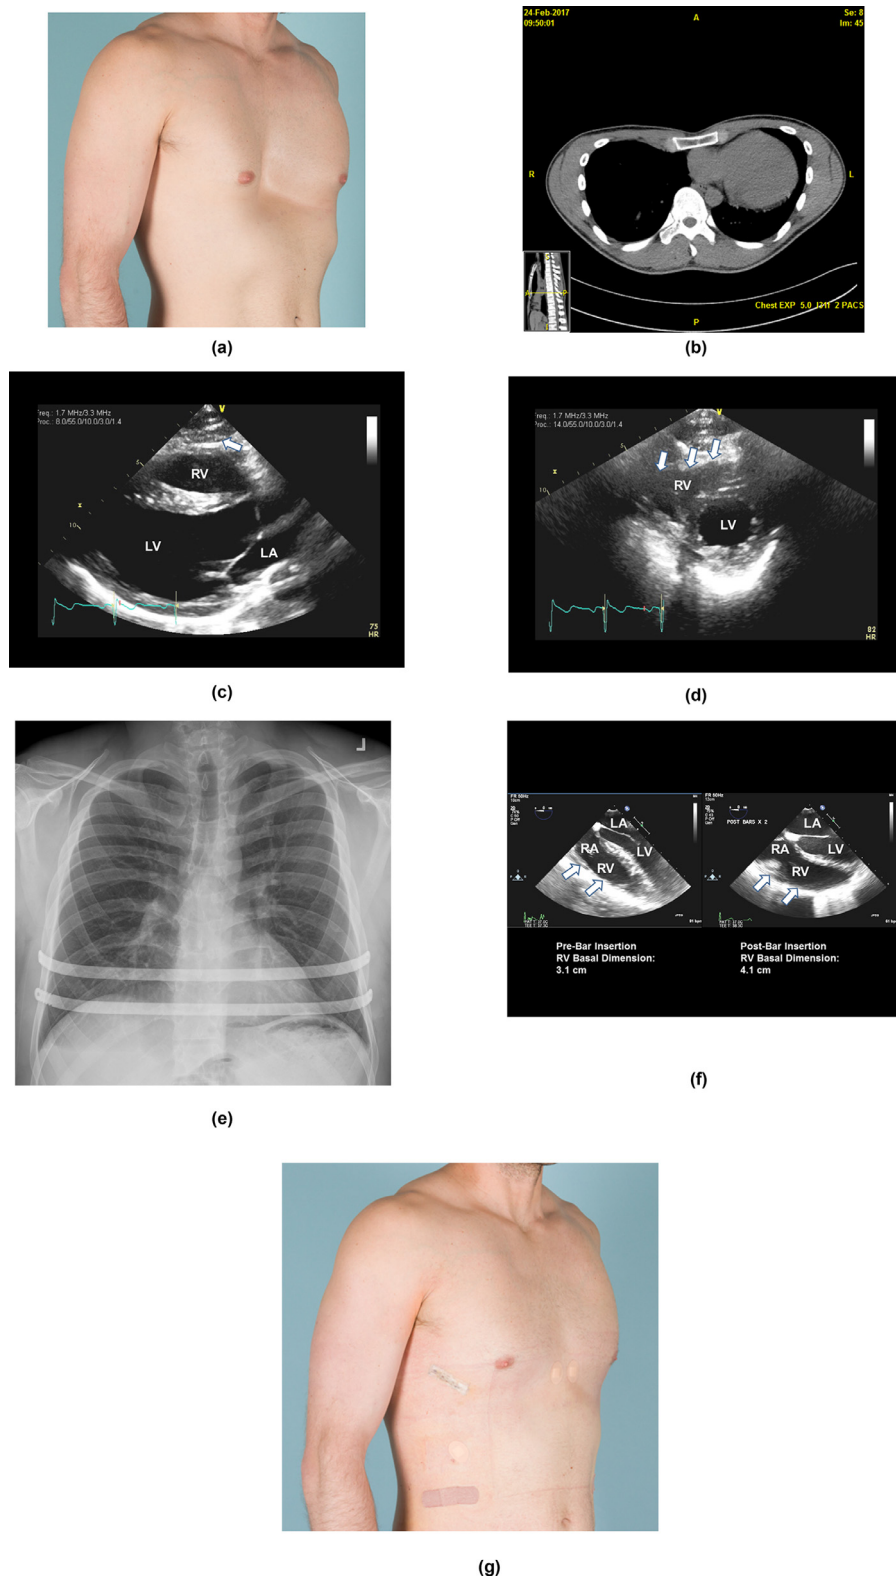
a–g (a) Photograph of 30-year-old man with severe pectus excavatum which developed in his early teens. He noted significant progression of exertional dyspnea and tachycardia over the past 5 years. (b) Subsequent CT scan showed deformity causing cardiac compression and Haller index of 5. CPET testing showed significant decrease in exercise capacity with peak anaerobic VO_2 of 60% predicted. An echocardiogram was performed (c) Parasternal long-axis transthoracic view demonstrated basal to mid right ventricular external compression (white-arrow) due to pectus excavatum deformity (d) Parasternal short-axis transthoracic view demonstrating significant right ventricular external compression (white-arrows) due to pectus excavatum deformity. (e) An MIRPE with 2 bars was performed for PE correction (f) Four-chamber transesophageal echocardiogram imaging was performed during bar insertion. The pre-bar insertion images (left) demonstrated basal to mid right ventricular external compression due to pectus excavatum deformity (white-arrows) with basal right ventricular dimension measuring 3.1 cm. (Right) Following 2 bar insertion the right ventricular compression improved (white-arrows) and the basal right ventricular basal dimension increased to 4.1 cm. (g) Excellent cosmetic results and complete resolution of symptoms was obtained postoperative.
